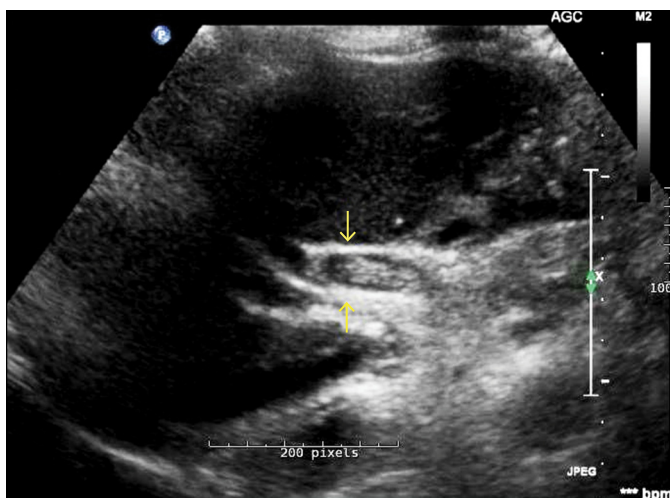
Abdominal ultrasound revealed long, parallel, echogenic, choledochal structures, initially thought to represent choledochal sludge without acoustic shadowing (between arrows). The ultrasound was subsequently re-read correctly as a characteristic finding of choledochal ascariasis.
